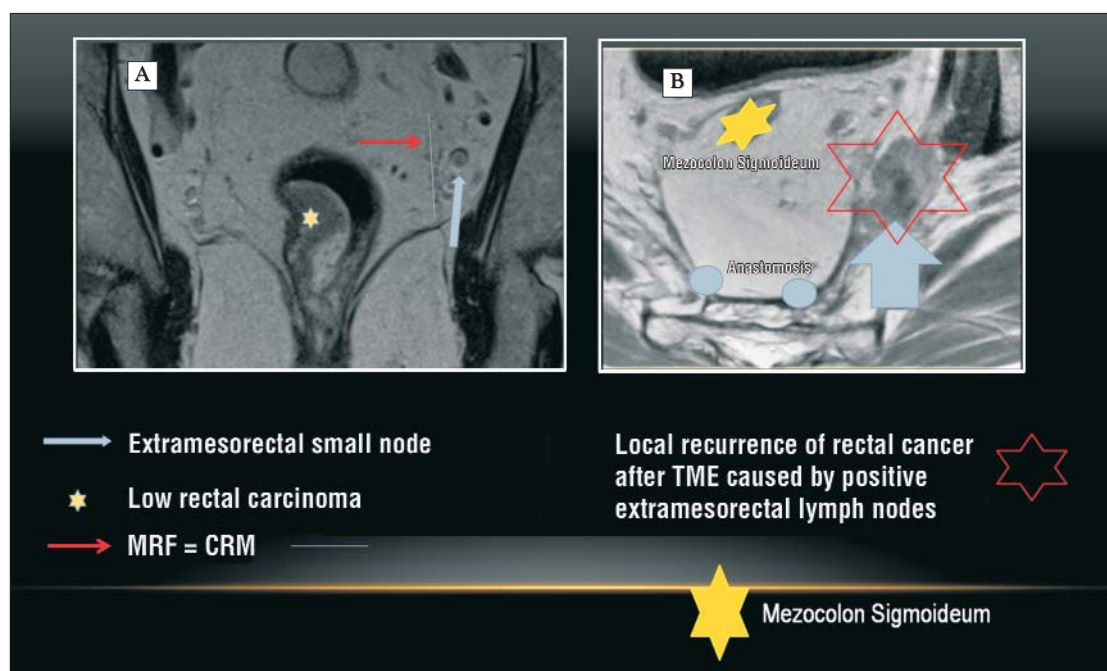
(A) T2w MRI before TME: Right T2 weighted lower rectal carcinoma. CRM- (yellow star) small NL on the left at 3 o'clock. The node was not removed through standard TME. (B) After 1 year after TME (without RCT). We see the same ganglion increased considerably as a sure sign of metastasis LG, (big blue arrow)
